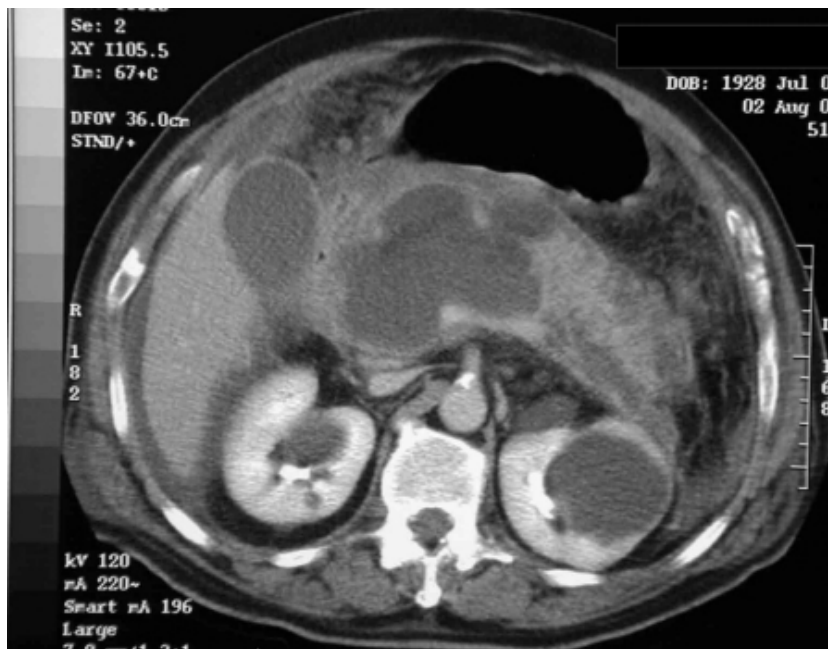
CT appearance of pancreatic necrosis
